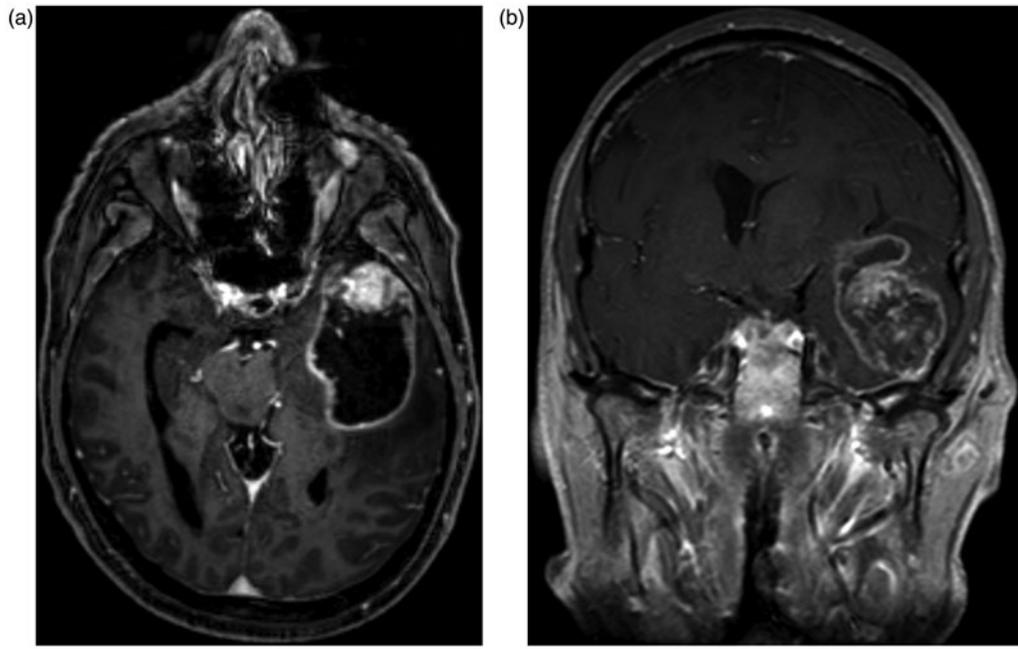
Large intrinsic cystic/necrotic left temporal lobe tumour with a hypervascular anterior nodule. (a) Axial MRI with contrast; (b) Coronal MRI with contrast.
